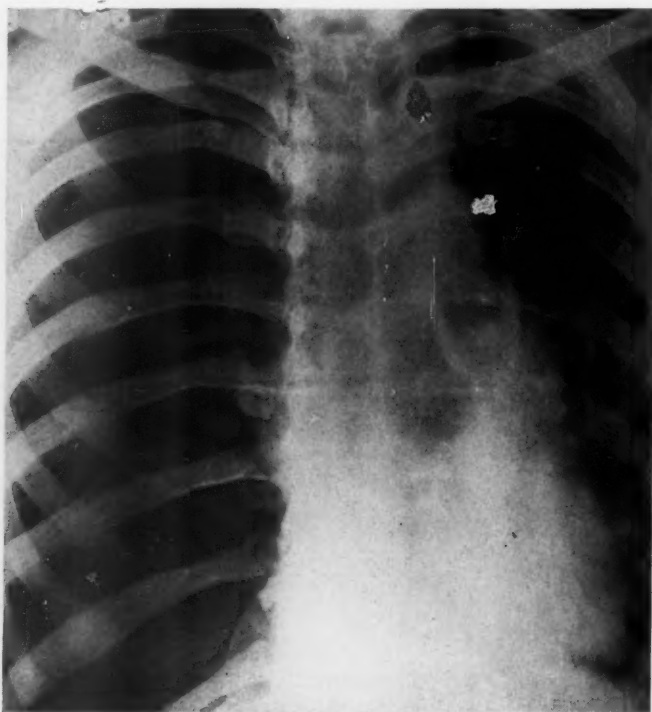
Case 5: Roentgenogram taken on admission. There is tension pneumothorax, with extreme mediastinal shift.
